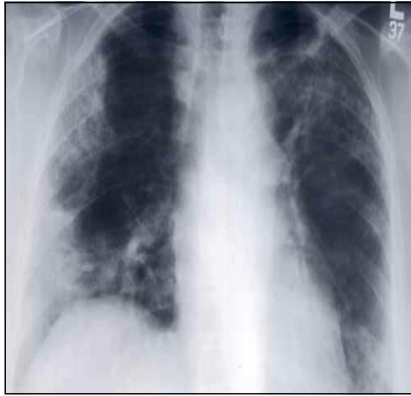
Chest radiograph showing bilateral pleural based infiltrate typical of bronchiolitis obliterans organizing pneumonia.
